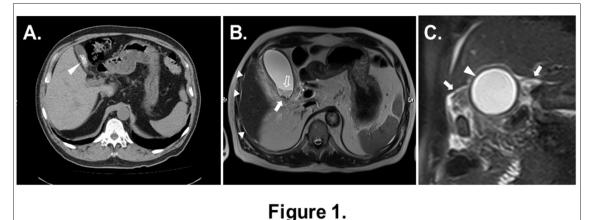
A select CT image at the level of the gallbladder (A) shows cholelithiasis (arrowhead) with a well-defined gallbladder wall. An axial T2-weighted half-fourier-acquired single-shot turbo spin echo (HASTE) MR image at the corresponding level (B) demonstrates multiple signal-void calculi (solid arrow) and a layer with a reduced signal intensity relative to the normal bile, suggestive of sludge (open arrow). The small amount of ascites around the liver is also shown (arrowheads). A select coronal T2-weighted HASTE with fat suppression MR image (C) demonstrates pericholecystic fluid collections (arrows) as well as acute inflammation of the gallbladder manifested by a thickened gallbladder wall (arrowhead).
